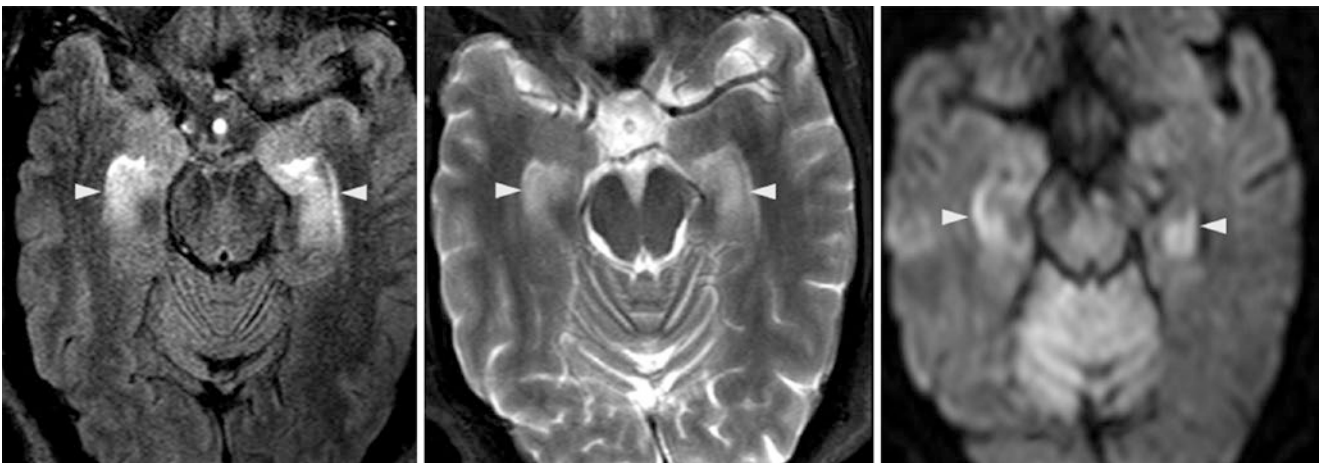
Comparison case of herpetic encephalitis. A 50-year-old with altered mental status underwent a 3 T MRI, which demonstrated edema of the hippocampi bilaterally (*arrowheads*) on axial FLAIR
